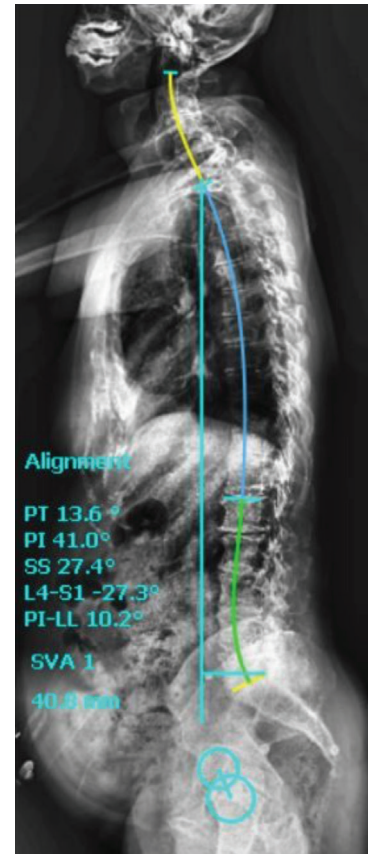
Preoperative lateral spine radiograph of patients treated with long level fusion surgery
